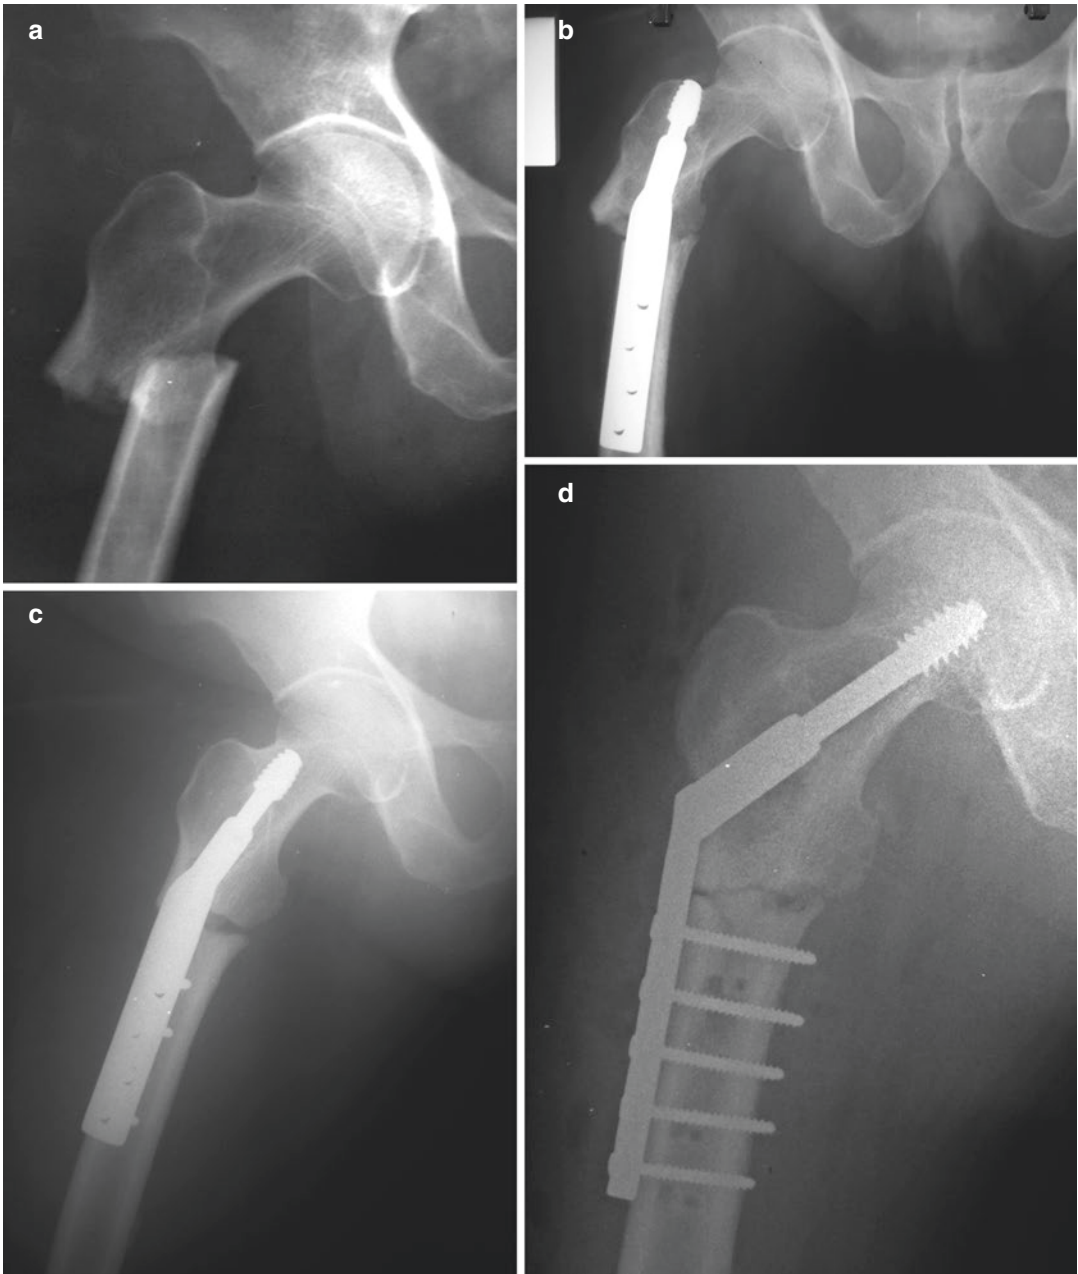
(a) X-ray of transverse high subtrochanteric fracture and (b, c) attempt at blind use of DHS. The compression screw is likely located on or in the superior neck.
